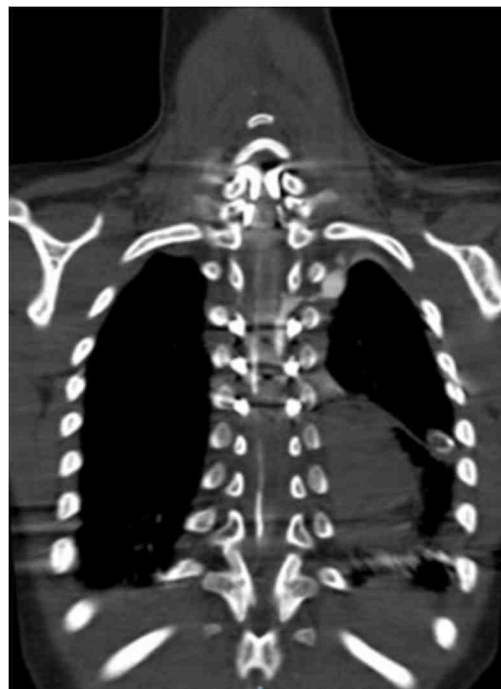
Dorsal spine CT, axial cuts, showing fracture in the body of vertebrae T2
